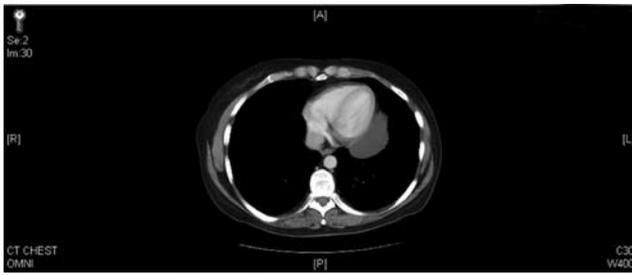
Initial CT demonstrating a 7 × 3 cm pericardial cyst of the posteroinferior aspect of the left cardiac border.
